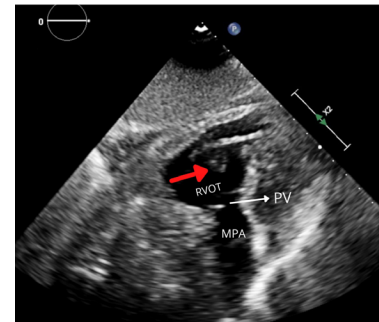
Two-dimensional transthoracic echocardiography (modified view) shows the location of the right ventricular thrombus (marked in red arrow) with respect to the right ventricular outflow tract (RVOT), pulmonary valve (PV) and the main pulmonary artery (MPA).
